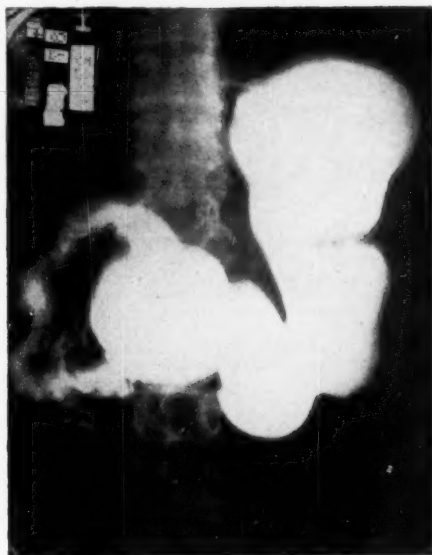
Roentgenogram of same stomach one year later, showing a deep incisura on the greater curvature as the only sign of the previous gastric ulcer.
